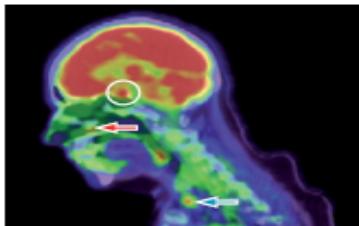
FDG-PET-CT scan.
